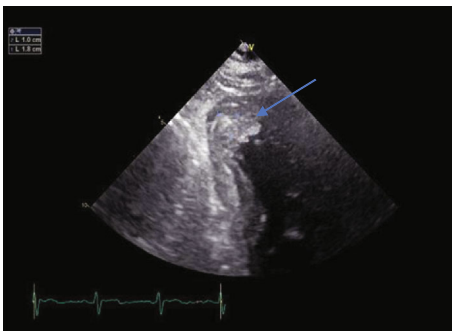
An echocardiogram: blue arrow - a mass suggestive of a thrombus.
